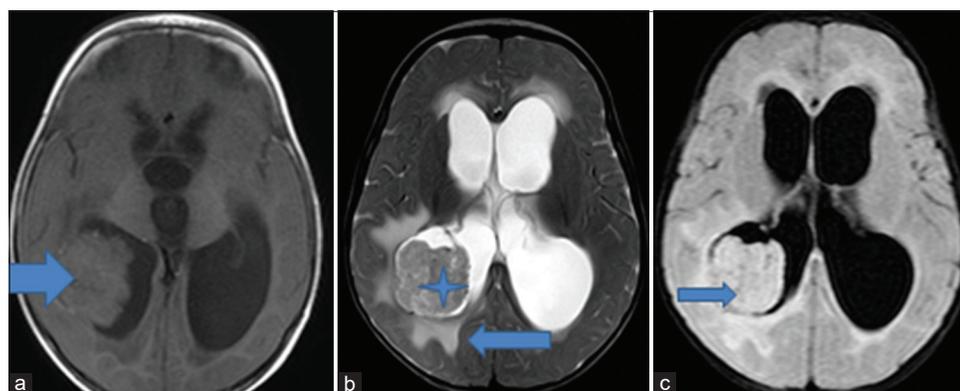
Axial section of MR images. (a) TIWI shows an isointense lobulated mass in the posterior horn of the right lateral ventricle extending to the trigone (blue arrow). (b) T2WI shows the same mass with the surrounding edema. (c) Fluid-attenuated inversion recovery (FLAIR) sequence shows the mass (blue star) compressing the brain parenchyma with periventricular ooze (blue arrow).
